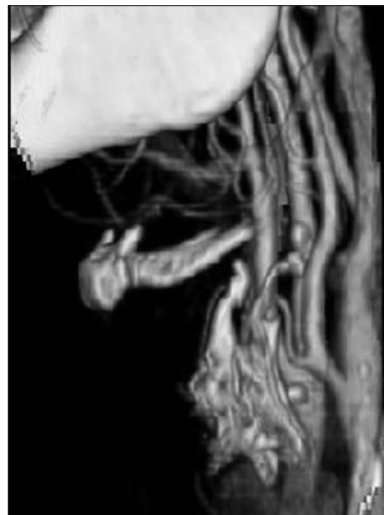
Three-dimensional reconstruction of the computed tomography taken 4 months after conclusion of the treatment protocol.
